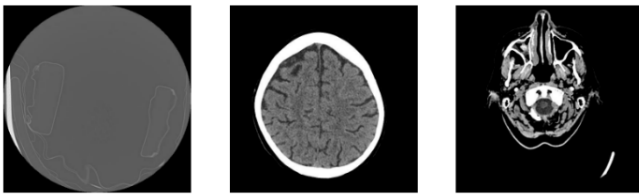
Brain CT image, preprocessed and segmented.
